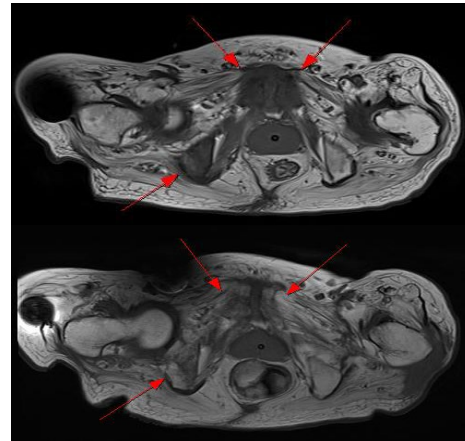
Pre, Postoperative MRI (Top: preoperative MRI, Bottom: postoperative MRI)
